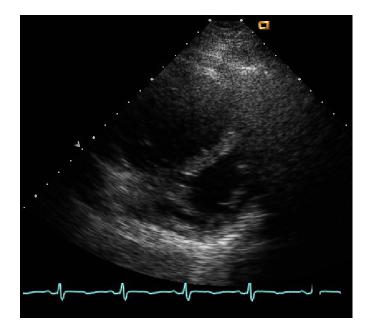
The same patient as in figure 3 with flattening of the septum seen in short axis view of echocardiographic image
